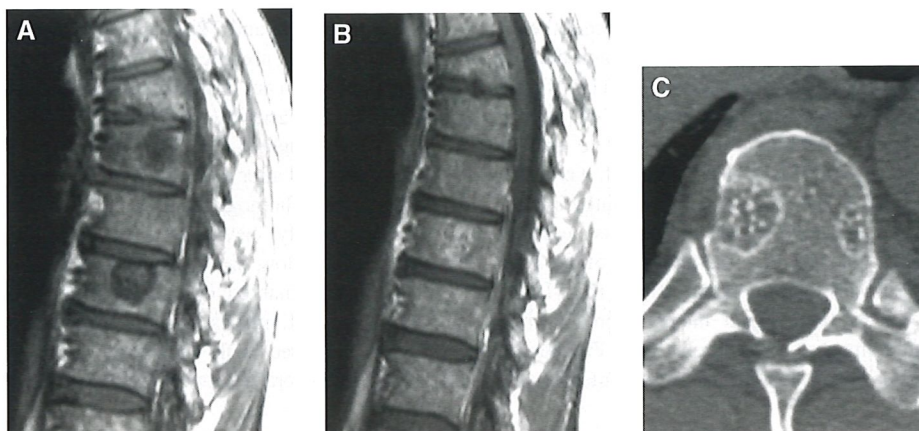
Atypical vertebral hemangioma. (A, B) Precontrast and postcontrast sagittal T1-weighted SE images of the thoracic spine of a 69-year-old man show two areas of low signal intensity that enhance after contrast injection. (C) Axial CT image shows the typical appearance of a vertebral hemangioma. Rarely, hemangioma can show a nonspecific pattern of decreased signal on T1-weighted SE images.
